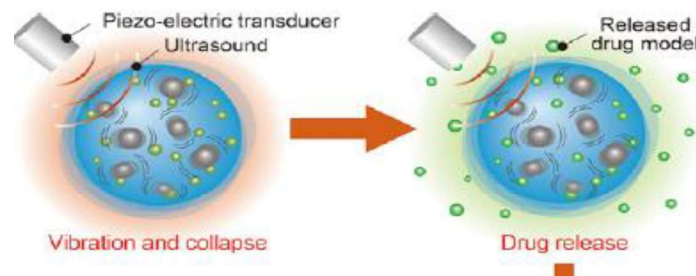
1 Example of ultrasound applied to a DDS's and the mechanism of cargo release [66].
